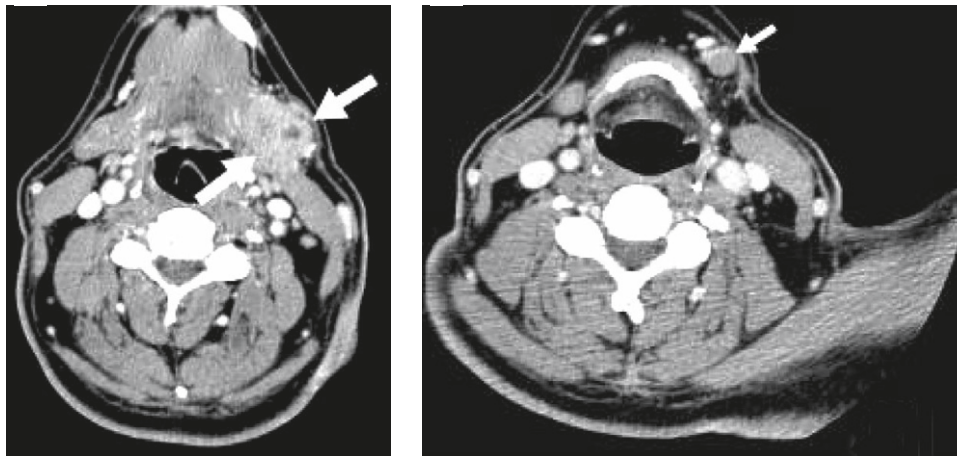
(A) Axial computed tomography revealed a mass with central necrosis in the left submandibular region (arrows). (B) One enlarged lymph node was found anterior to the mass (arrow).
